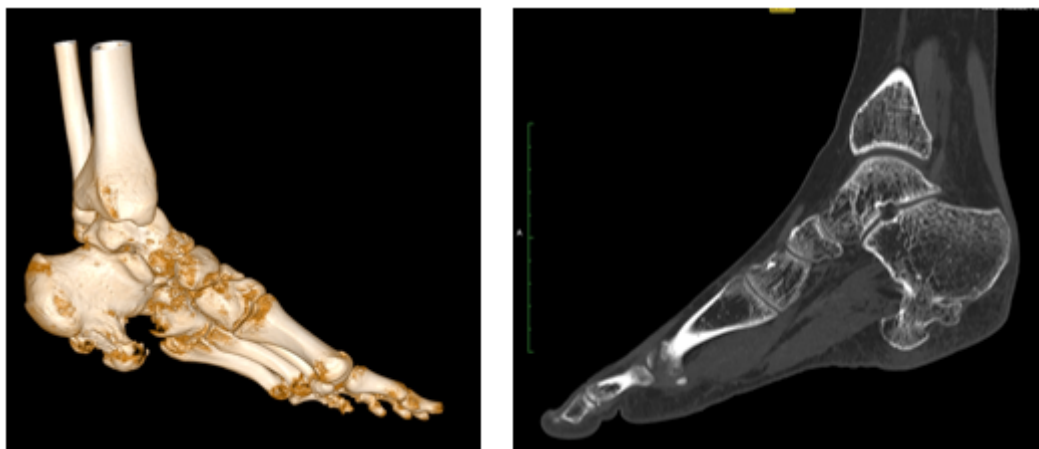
CT scan of the left foot showing left calcaneal bony mass.
